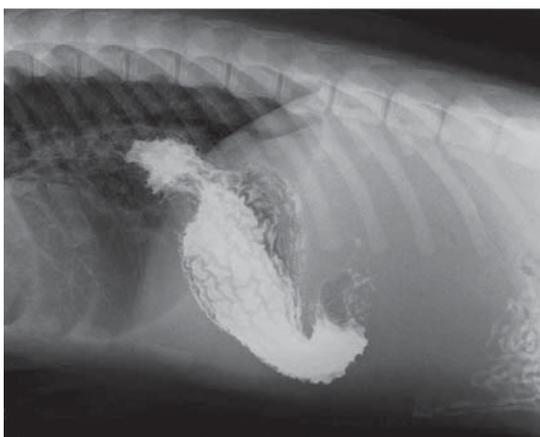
Lateral thoracic radiograph using contrast to demonstrate herniation of the gastric cardia and fundus through the diaphragm into the caudal thorax.
